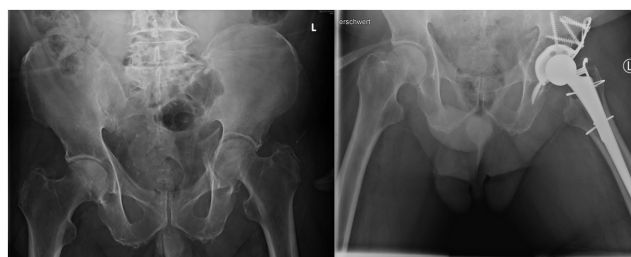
Complex acetabular fracture pre- and post-operative. For stabilization, a THA with MUTARS® RS CUP system was used: this fracture with affection of the major trochanter of a 76 years old male patient based on an epileptic seizure. In the CT scans and intraoperatively, there was a problem of multiple dislocated fracture fragments of the acetabular bottom. After an acetabular bottom plastic, an MUTARS® RS CUP and a CLS® stem were inserted. After the operation, mobilization was only allowed by partial weight-bearing on the left side which was not possible to realize for the patient.
